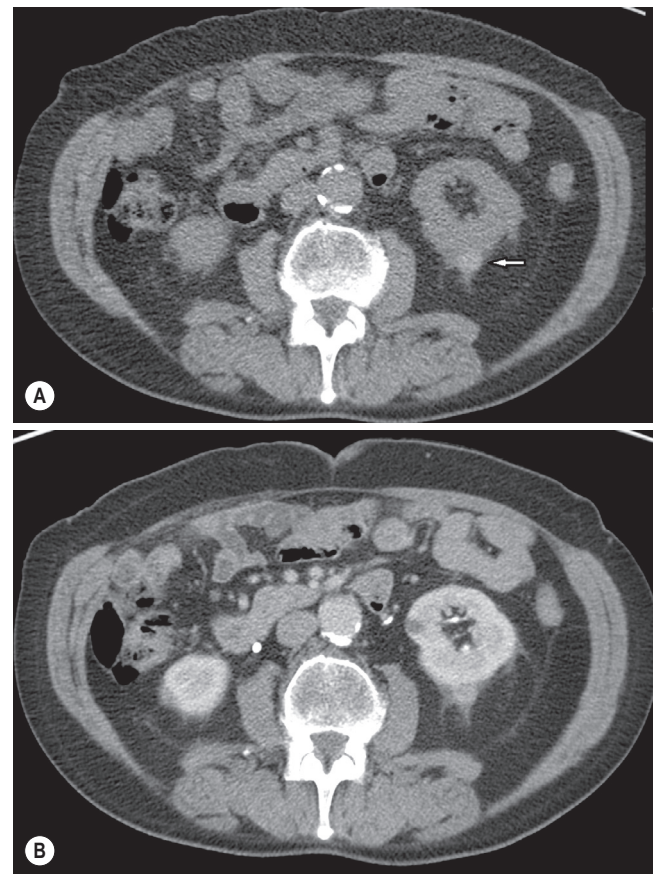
■ Haemorrhagic cyst of the kidney. Pre-contrast (A) image reveals high-density, round, smooth mass in the right kidney (see arrow). There is minor inflammatory change surrounding the lesion which may be due to recent trauma, or infection. (B) Following contrast medium there is no significant change in the appearance or density of the mass. It is easy to misdiagnose a haemorrhagic cyst as a solid renal mass, and review of a non-contrast CT is vital to evaluate the presence of enhancement.
